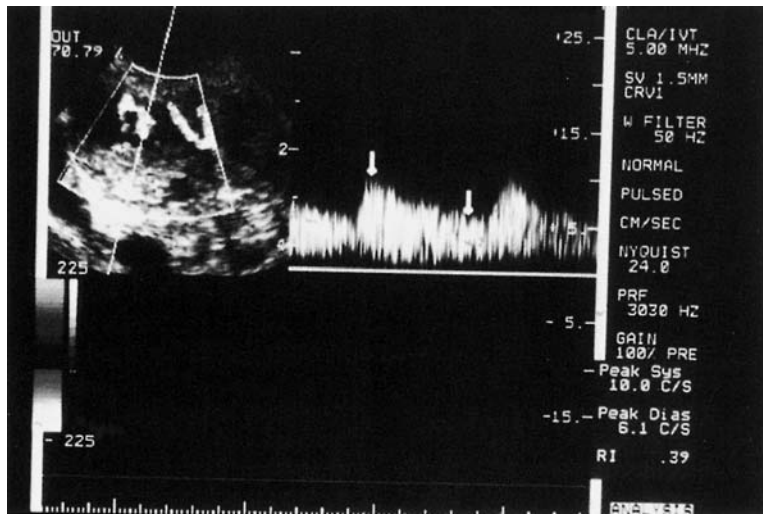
Randomly dispersed small vessels detected by color Doppler in the central portion of a solid adnexal mass
